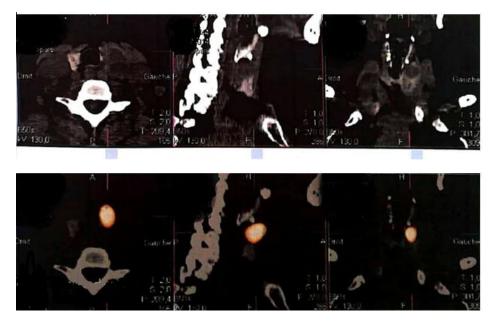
The accurate localization of intrathyroid parathyroid adenoma with SPECT/CT
